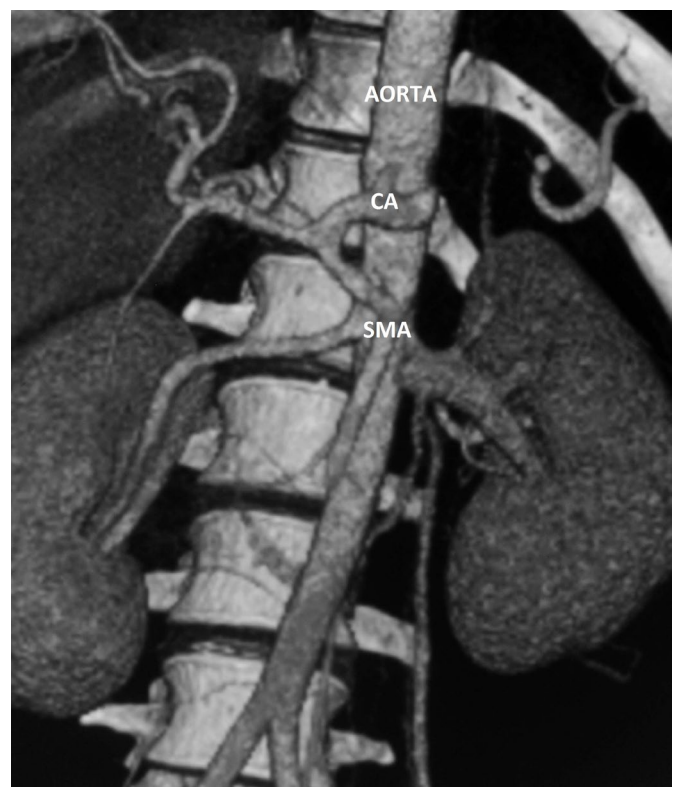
CTA: normal major abdominal arteries (CTA: CT angiography; CA: Celiac axis; SMA: Superior Mesenteric Artery).
